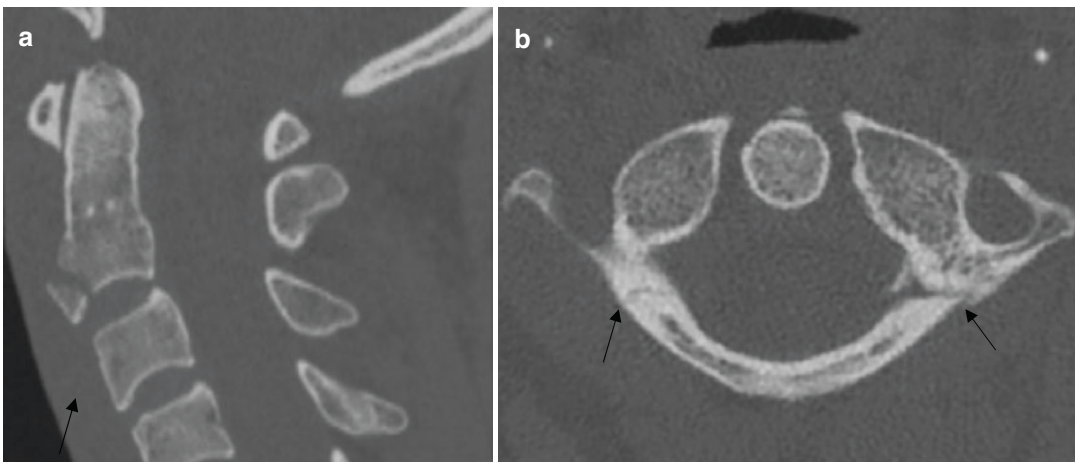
(a) Sagittal CT demonstrates C2 teardrop fracture (black arrow). (b) Axial CT in same patient demonstrates bilateral C2 posterior arch fractures (black arrows) with extension into the transverse foramina (not shown here). (c) Corresponding sagittal STIR demonstrates very faint bright line (white arrow) corresponding to teardrop
